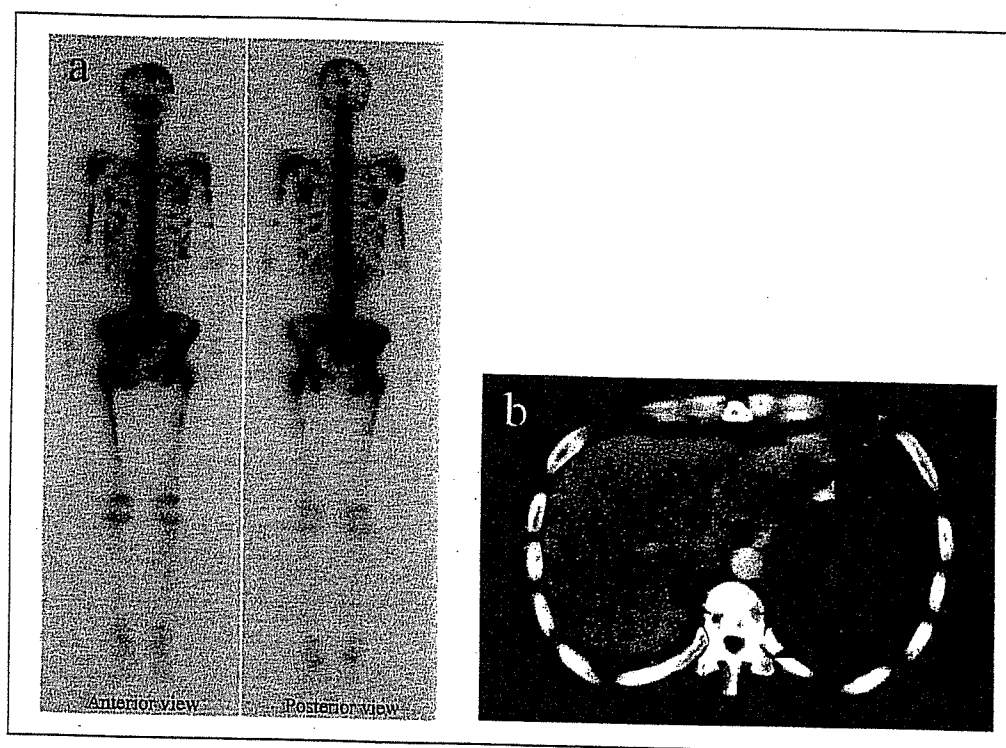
Typical radiological findings of bone lesions in disseminated carcinomatosis of the bone marrow associated with gastric cancer (case 9). The bone scintigraphy showed multiple hot spots throughout the entire skeleton (a). These bone lesions were composed predominantly of osteolytic bone destruction, which was disclosed by CT (b, arrow head).
